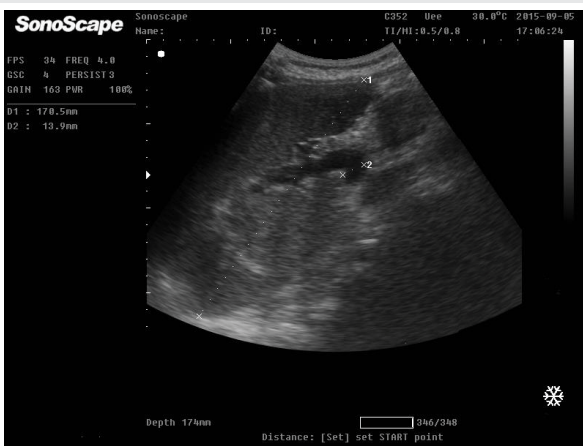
Abdominal ultrasonography revealed splenomegaly with bipolar diameter 170.5mm (normal up to 130 mm) and increased splenic vein diameter 13.9mm (normal up to 8-10mm).
